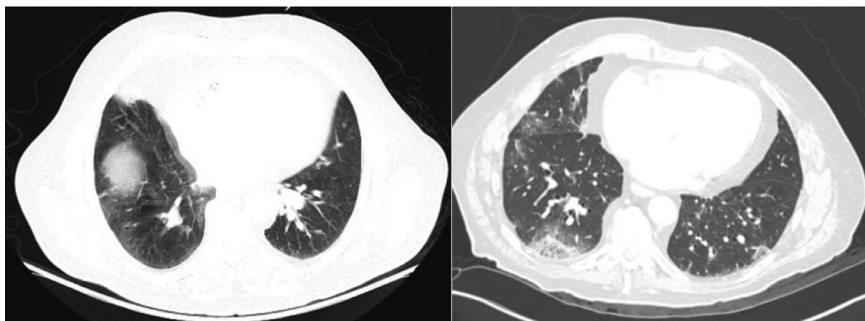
A 45-year-old woman presenting to the emergency department with abdominal pain and cough. Abdominopelvic CT showed extensive bilateral ground-glass opacities. Chest radiologist confirmed these findings were consistent with COVID-19 infection. Subsequent COVID-19 PCR test was positive, and patient had elevated ferritin, D-dimer, ESR, and CRP. Figure 2b. A 82-year-old male man presenting to emergency department after fall in bathroom, with no respiratory symptoms. Abdominopelvic CT showed patchy peripheral multilobar lung base ground glass opacities. Chest radiologist confirmed these findings were consistent with COVID-19 infection. Subsequent COVID-19 PCR test was positive, and patient had elevated ferritin, D-dimer, ESR, and CRP. Figure 2c. A 80-year-old man presenting to the emergency department with abdominal distention and concern for small bowel obstruction. Abdominopelvic CT showed moderate patch groundglass and atelectasis. Chest radiologist confirmed these findings were possibly consistent COVID-19 infection. Subsequent COVID-19 PCR test was positive. Figure 2d. A 81-year-old-man presenting to the emergency department with cough and abdominal pain, history of right nephrectomy. Abdominopelvic CT showed trace pleural effusion and likely airways inflammation; chest radiologist assessed these findings as not consistent with COVID-19 infection. Subsequent COVID-19 PCR test was negative.
